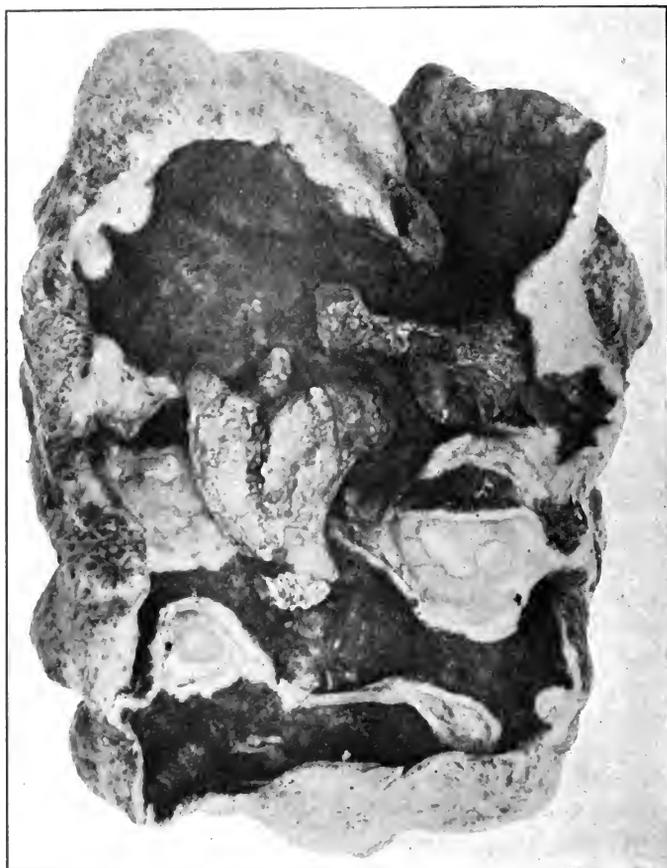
PYONEPHROTIC KIDNEY, CONTAINING LARGE PHOSPHATIC CALCULI, AS DEMONSTRATED BY X-RAYS, NEPHRECTOMY, MARCH, 1909. Patient had marked pyuria and had been treated for bladder trouble for several years. (Author's case.)
